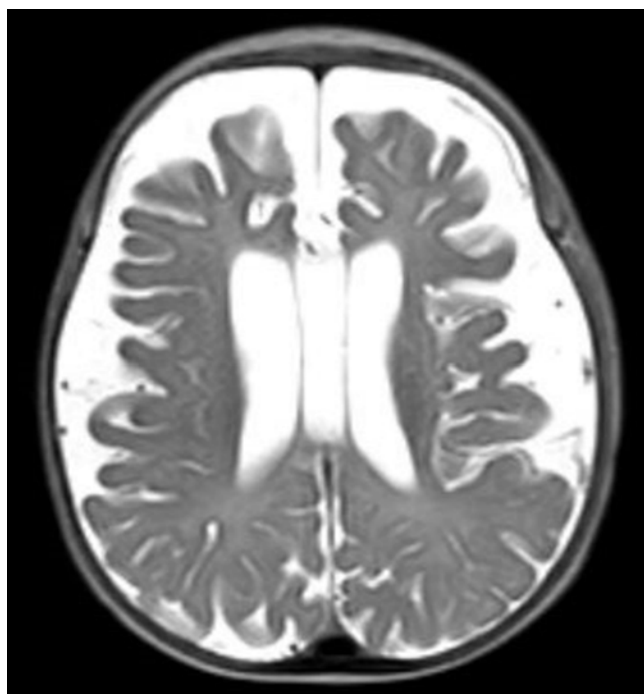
Axial T2-weighted MR image of an infant with BESS. There is enlargement of the SAS, specifically along the bilateral frontal lobes. Patients may or may not have mild ventriculomegaly as well.
